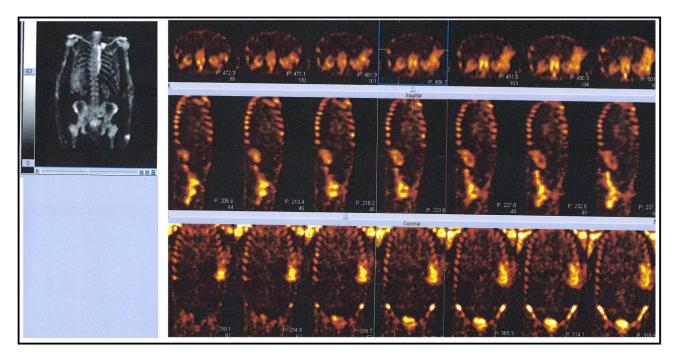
Patient's 2 SPECT imaging. Spleen but no cardiac uptake is confirmed.
